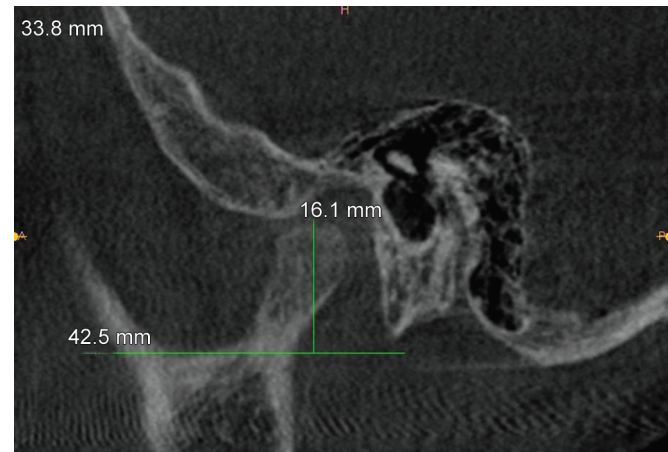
Cone-beam computed tomography (CBCT) scan of condylar height posttreatment
